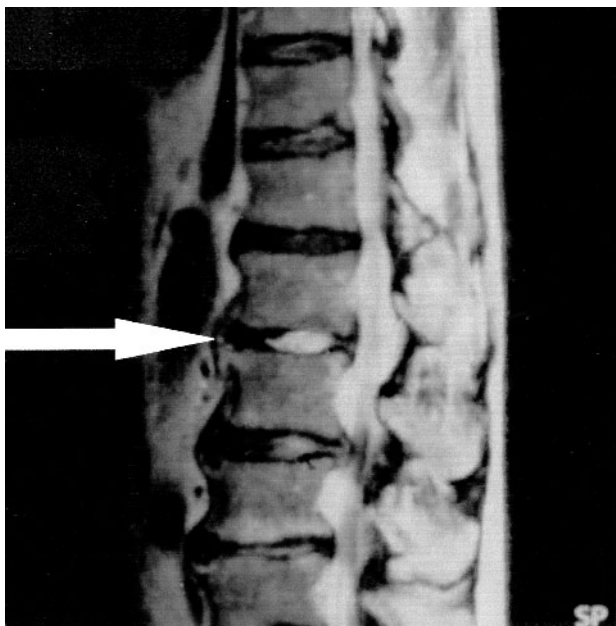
T2 weighted MRI shows increased signal indicating fluid in L2/L3 disc space. Degenerative disc disease is also noted.
